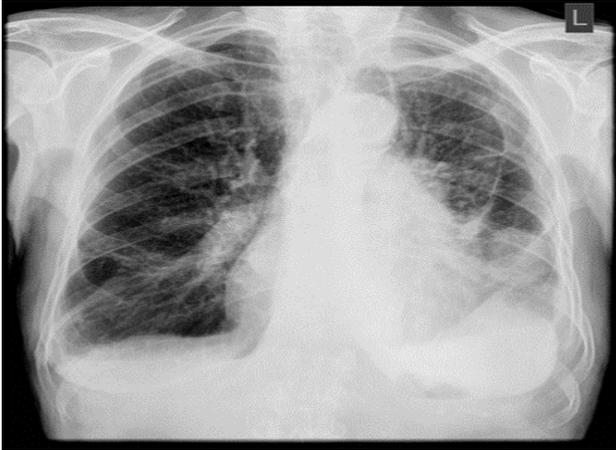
chest x-ray. left side hydro-pneumothorax with lesion in the left lung lower lobe.
